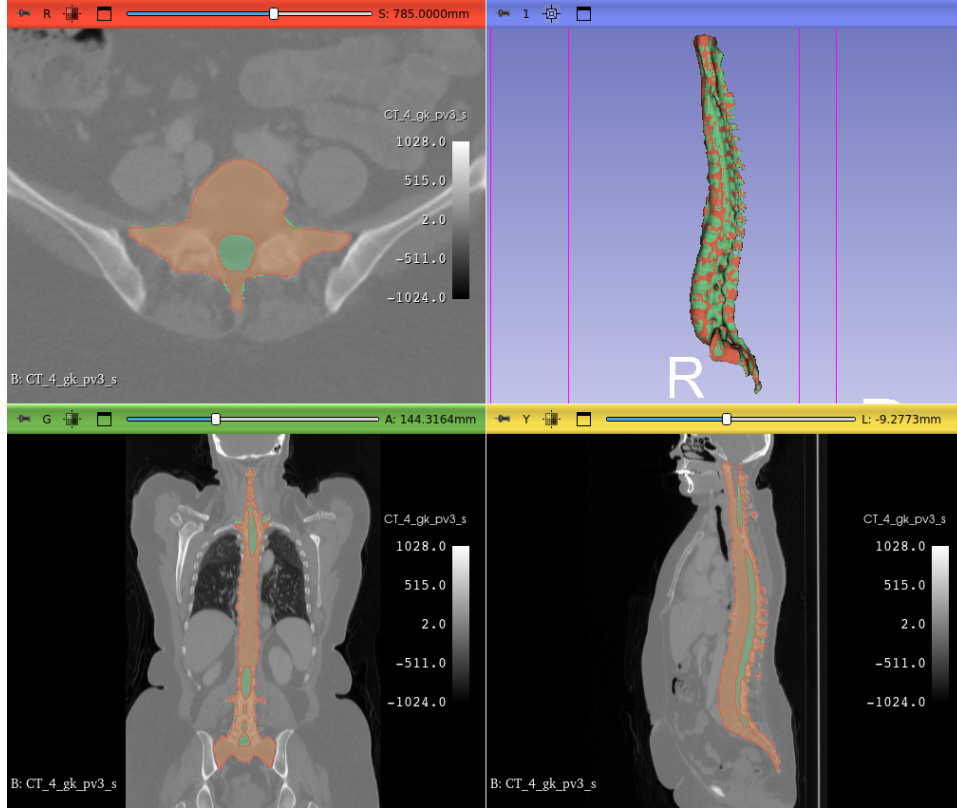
Example of *fill_holes* process for segmentation shaping. In the image are represented a CT image (black and white) and two spine segmentation: in red is represented the original spine segmentation, and in green the spine segmentation after the application of the filling process. All the elements are projected on the three medical imaging planes and on top right a 3D segmentation rendering is shown.
